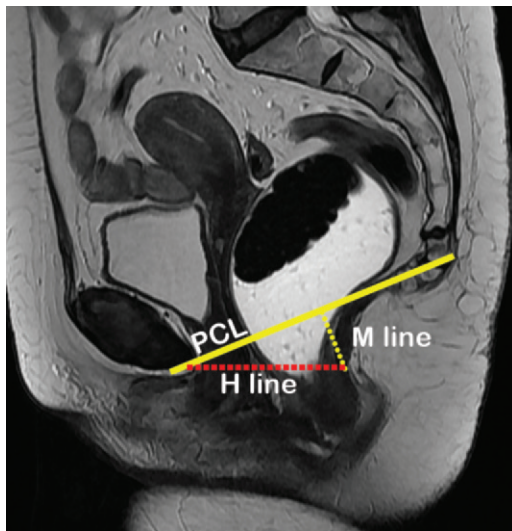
Normal pelvic floor anatomy in a 42-year-old female patient. Midsagittal T2-weighted MR image obtained with the patient at rest shows the PCL (solid yellow line), *H* line (dotted red line), and *M* line (dotted yellow line). The puborectalis muscle is located just posterior to the anorectal junction, and the levator plate is parallel to the PCL.
